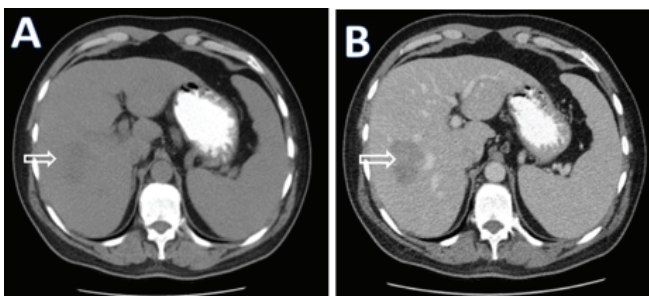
Unenhanced (A) and enhanced (B) axial computed tomography images of a metastatic liver lesion (arrow) in segment 7 of the right lobe
